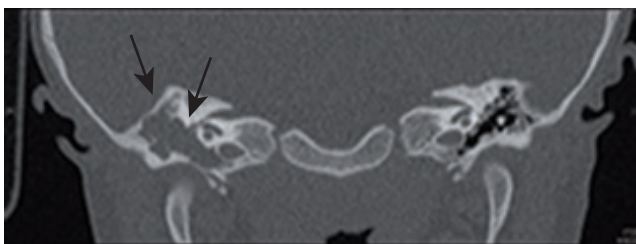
Coronal CT scan of a 5-year-old child. The arrow indicates extensive congenital cholesteatoma eroding the anterior attic and the 1st genu of the facial nerve.
